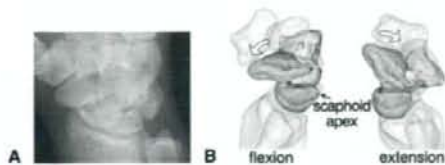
The mobile type proximal pole nonunion (B3 type 2, case 7). A The semipronated view of the plain radiograph does not show clear relationship between the fracture line and the scaphoid apex. B Three-dimensional animation shows a marked interfragmentary motion during flexion-extension motion. The proximal scaphoid is fixed, and the other bones are moving (these videos can be viewed at the *Journal's* Web site, www.jhandsurg.org).
